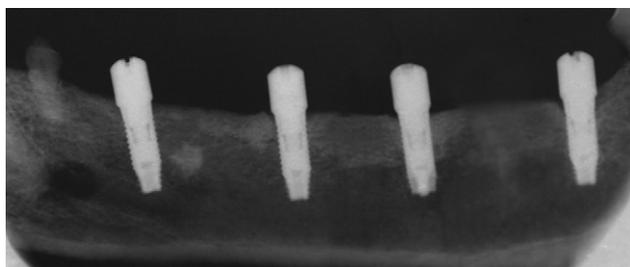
Radiographically, crestal bone level is maintained around the implant necks.
